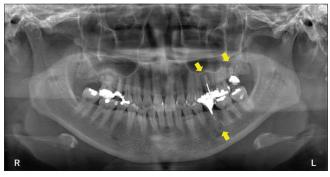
Panoramic radiograph shows radiolucent areas at the apices of the mandibular left second premolar and maxillary left second premolar and second molar
